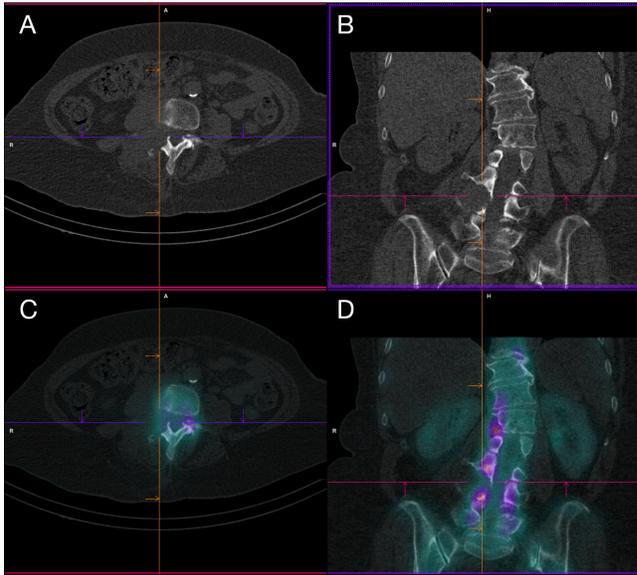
SPECT/CT taken 3 hours after IV administration of ^{99m}Tc MDP gives both structural and functional information. A) and B) Axial and coronal bone window CT acquisition. C) and D) Axial and coronal bone window fused SPECT/CT.
